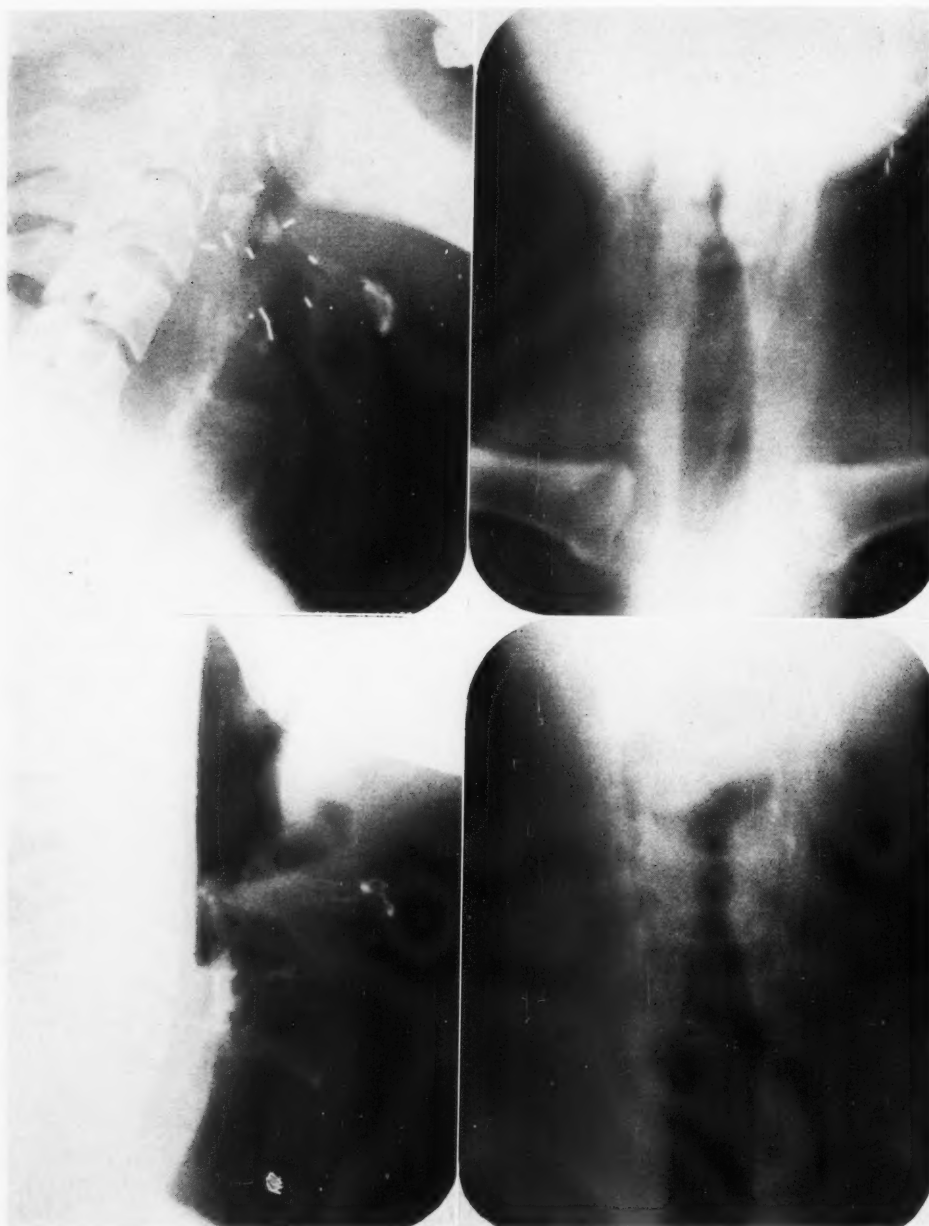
A (*upper left*). X-ray demonstrating broadening of retropharyngeal space.
